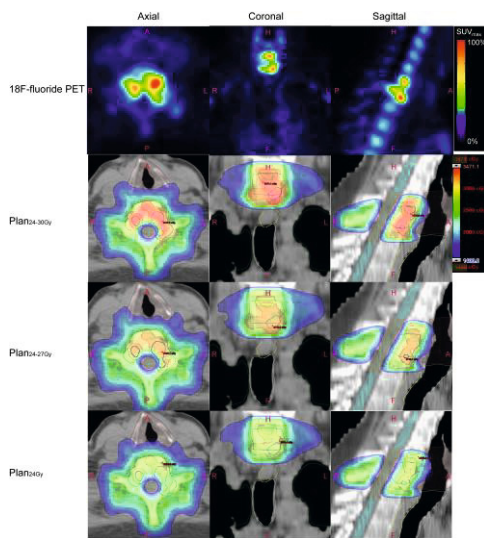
PET/CT images and corresponding treatment plan dose distribution images from a patient with spine oligometastases. The dose distribution is shown in axial, coronal and sagittal projections; with color scale of red representing high doses and blue representing low doses. Plan_{24-300y} shows a stratified dose distribution with a dose hot spot occupying the PTV_{MATV} (red) contour, with dose dropping in the “non-boost” region (i.e., PTV_{reg}). The color wash for dose scaling was set in the range of 1400 – 3471 cGy. The maximum point dose (0.03cc) in the Plan_{24-300y} is confined within the PTV_{MATV}. In contrast, the maximum point dose (0.03cc) in the Plan_{24-300y} is located outside the PTV_{MATV}. Anchoring the “hot spot” as close as to the SUVmax was accomplished by defining MATV in the Plan_{24-300y}. This could have a radiobiological advantage as the most biologically active tumor volume would then receive the highest radiation dose. Abbreviation: A: anterior; P: posterior; L: left; R: right; H: head; F: feet.
